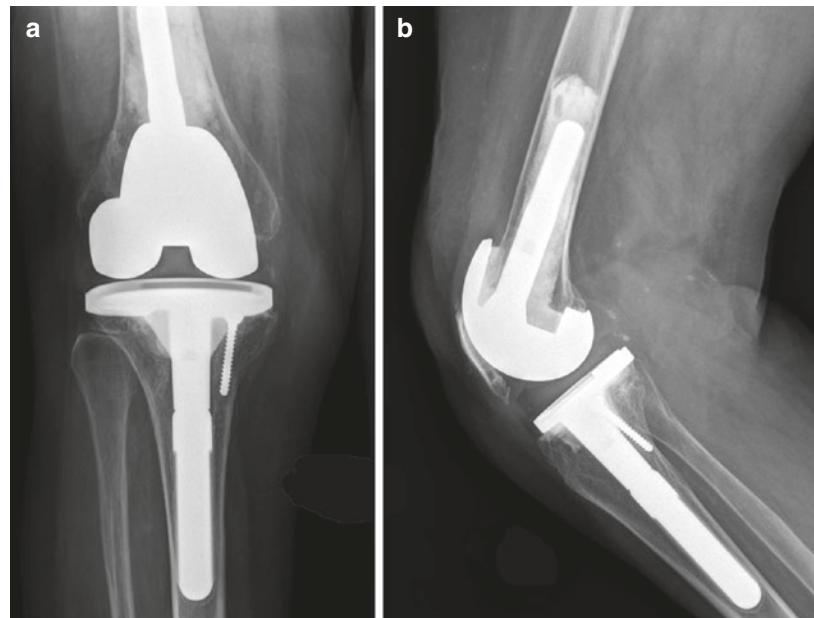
4-week postoperative (a) anteroposterior (AP) and (b) lateral radiographs demonstrating restoration of proximal tibial bone
